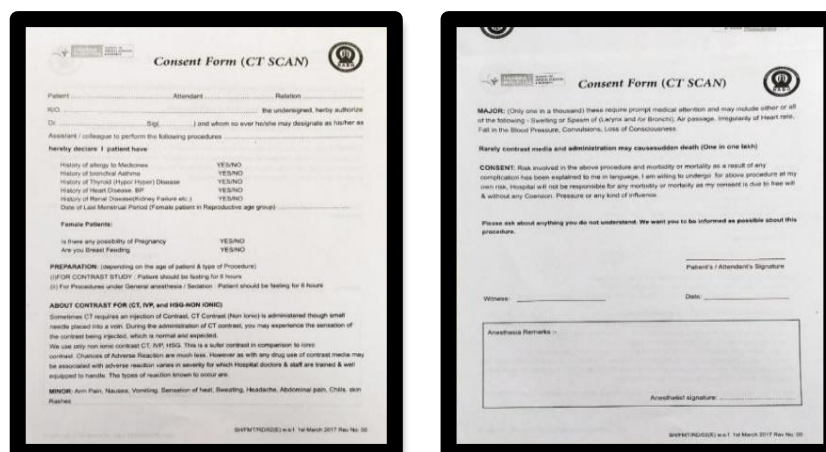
During procedure consent form in CT scan
